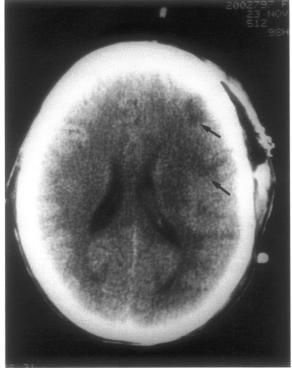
Case 1, a 68-year-old male with squamous cell carcinoma involving the temporal bone. Noncontrast CT scan on postoperative day 5 reveals a right middle carotid artery infarct involving the temporal lobe.
